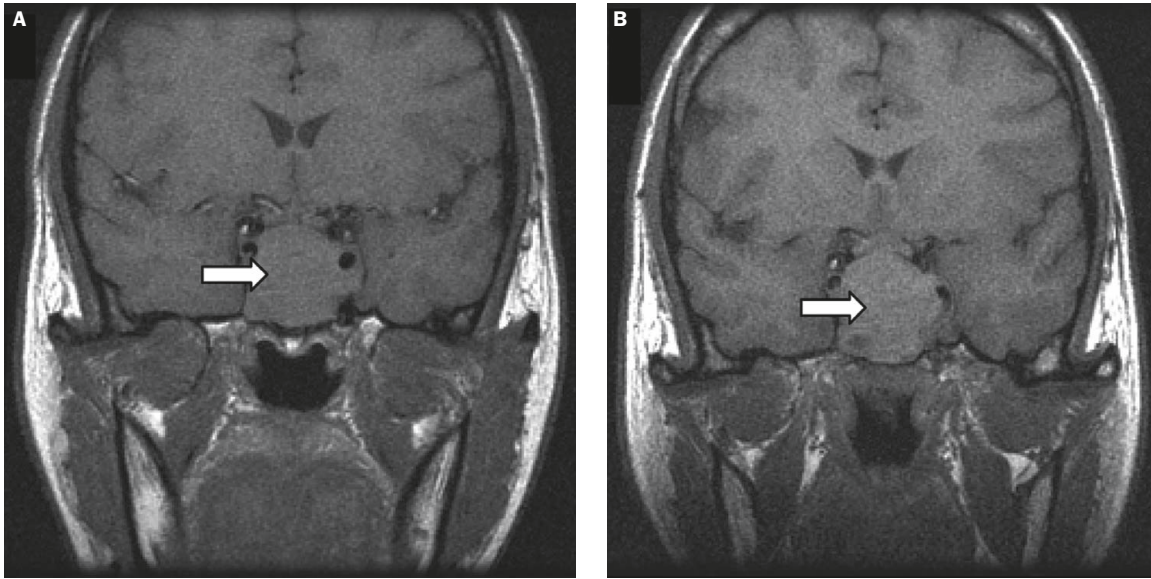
Magnetic resonance imaging coronal T1-weighted images show pituitary macroadenoma (arrow) without evidence of pituitary apoplexy: (A) before thyrotropin-releasing hormone (TRH) test; (B) after TRH test.
